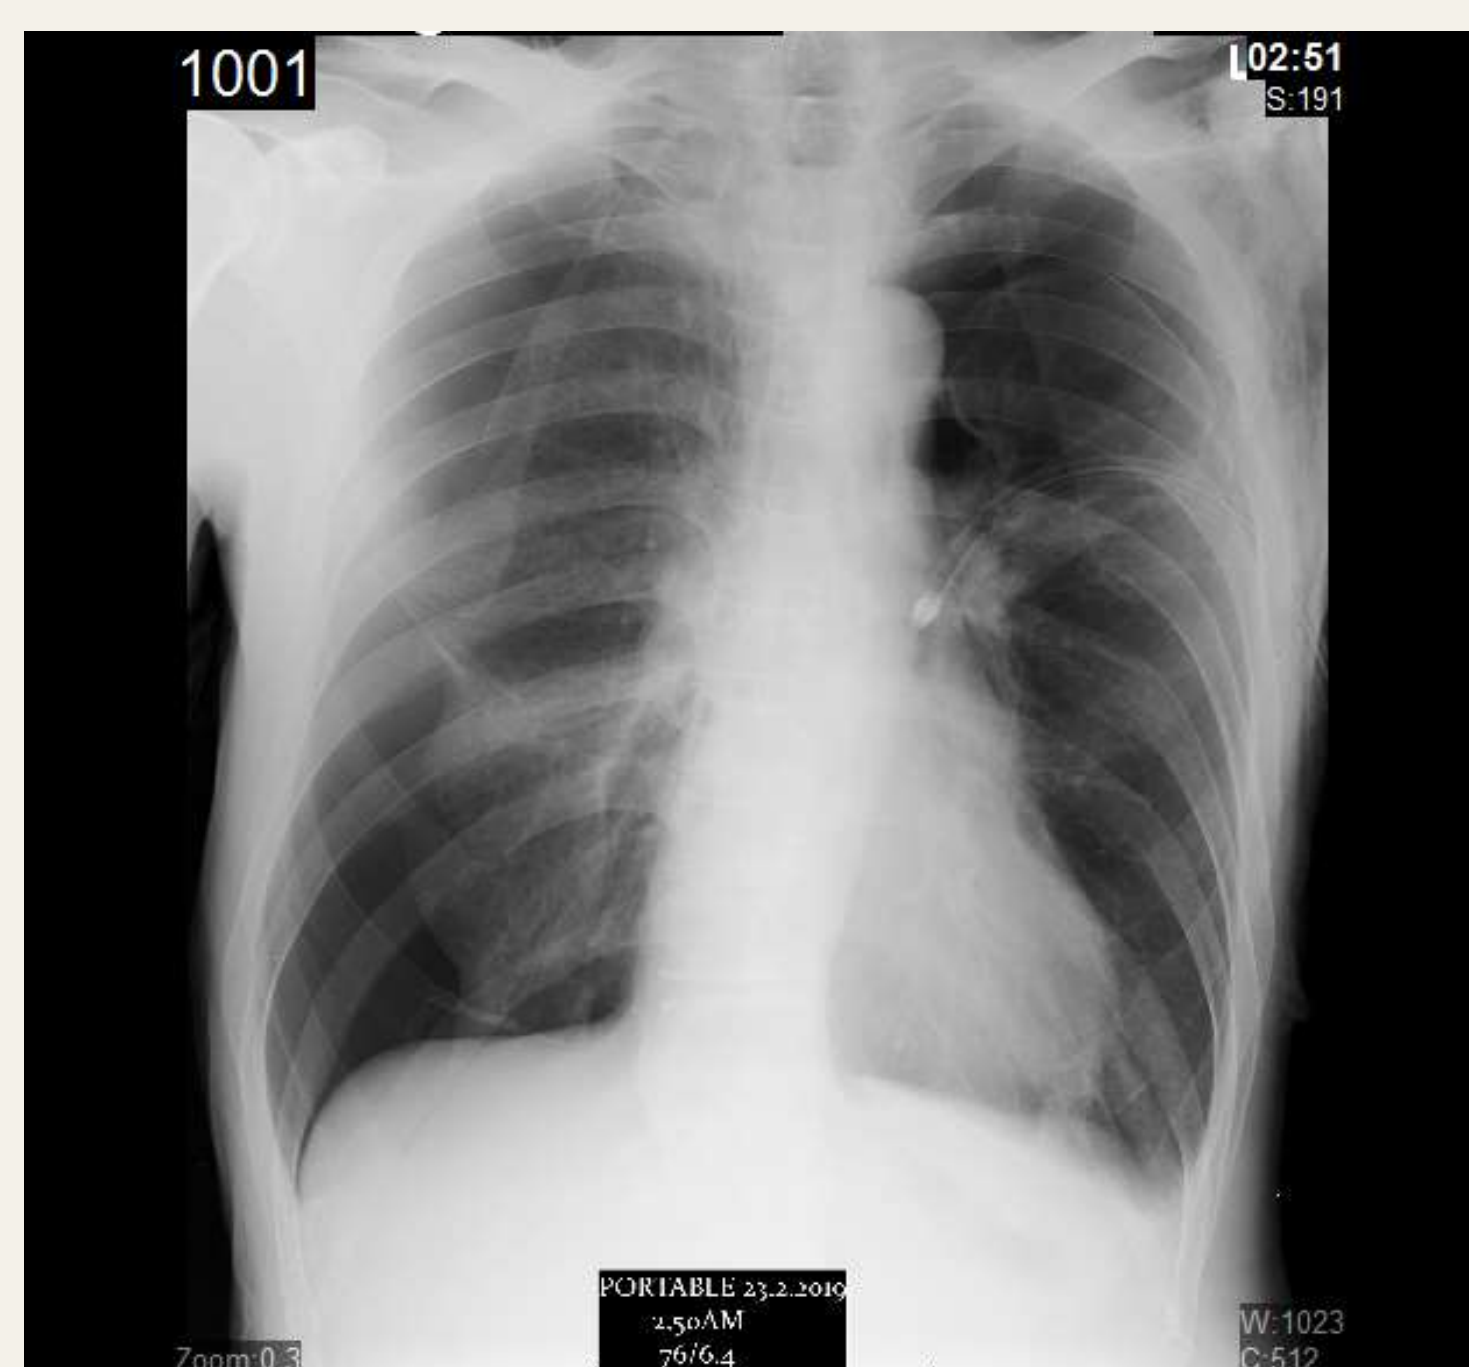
Chest Xray post left chest tube insertion
